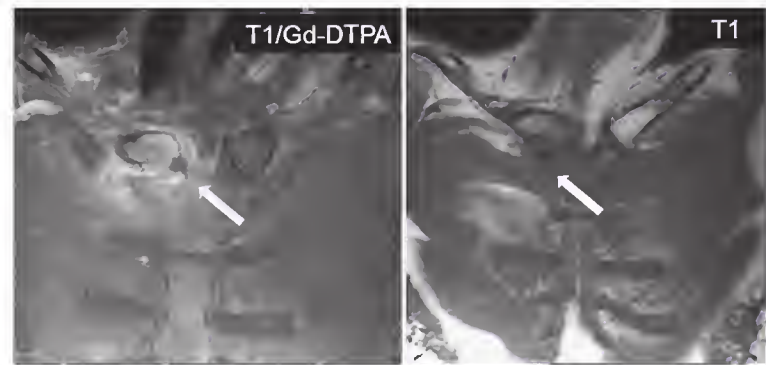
Magnetic resonance images showing costochondritis (arrow) in a patient with ankylosing spondylitis.
